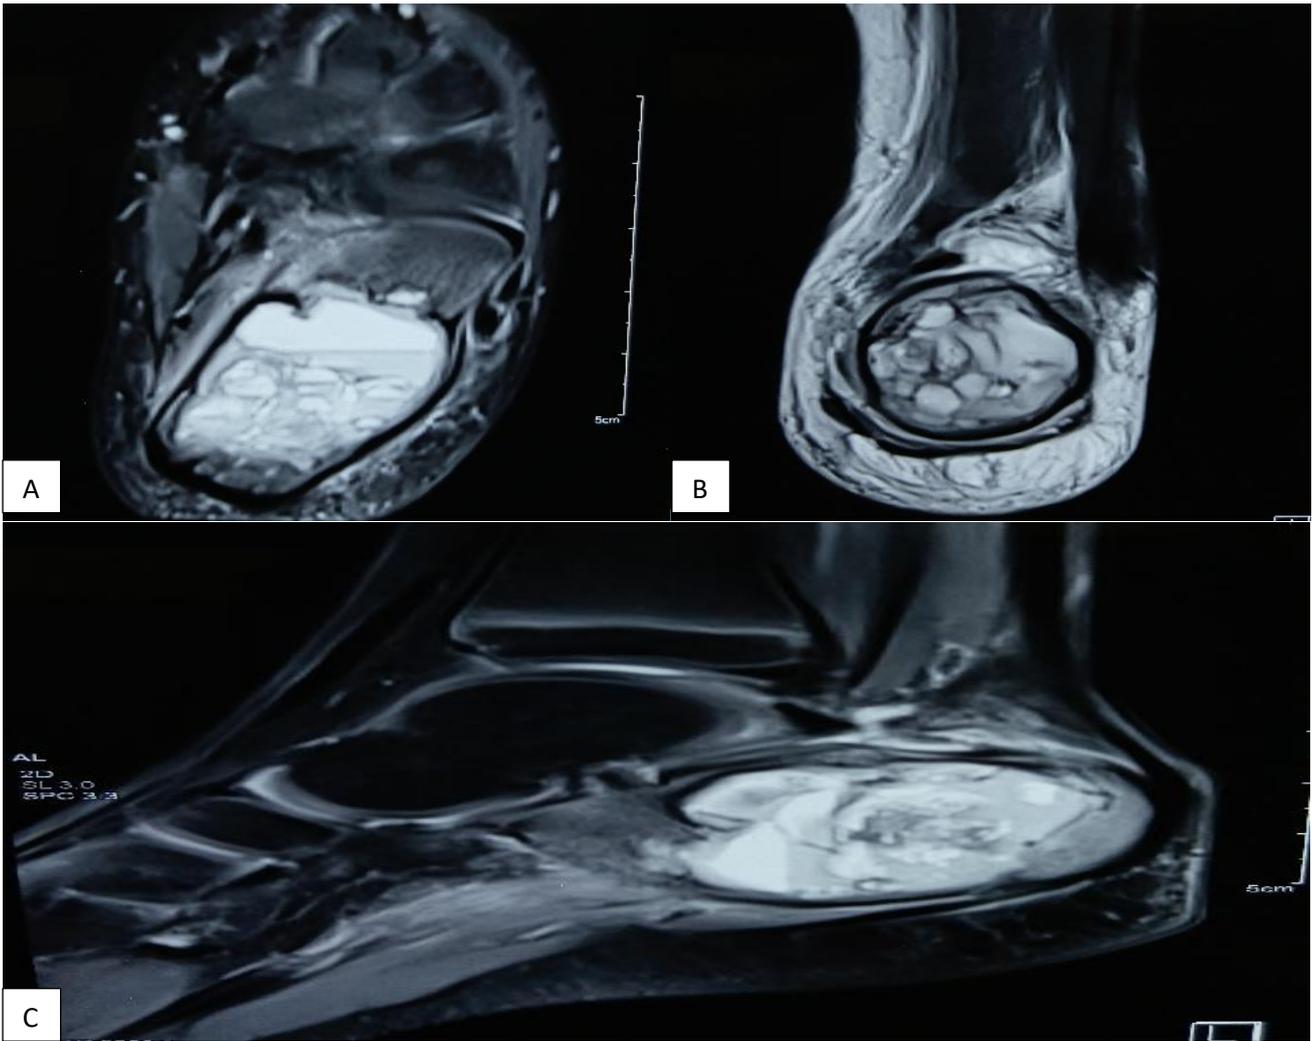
(A-C): A-MRI of left calcaneus coronal view showing multiple fluid-fluid levels. B-MRI of Left calcaneus axial view showing multiple fluid-fluid levels. C-MRI of Left calcaneus sagittal view of multiple fluid-fluid levels.
